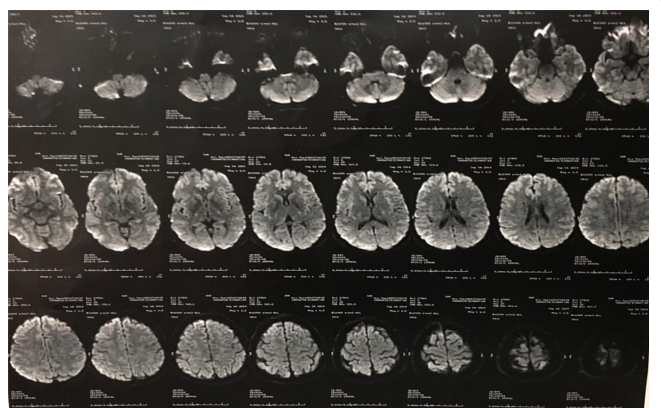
Normal MRI findings
